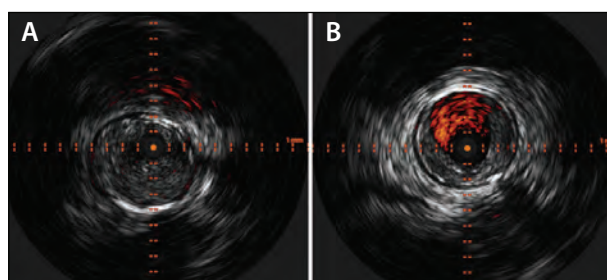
Intravascular ultrasound of the superficial femoral artery before (A) and after (B) treatment with the Auryon system and adjunctive therapy.
